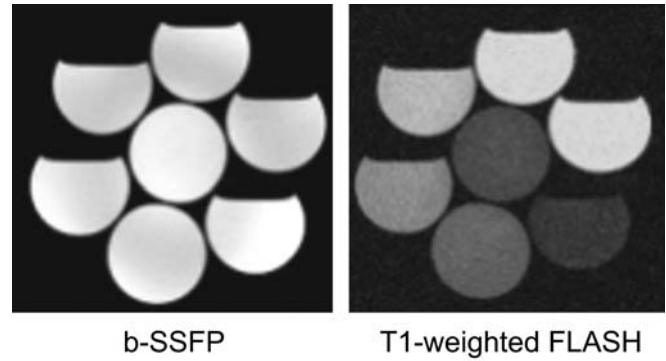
The b-SSFP and nb-SSFP (T1-weighted FLASH) image of bottles filled with water and different concentrations of a conventional gadolinium-based contrast agent. Since reduction of T1 and T2 is similar the ratio T2/T1 is nearly independent of the concentration of the contrast agent leading to comparable signal intensities for b-SSFP. A clear T1 contrast can be observed for T1-weighted FLASH
